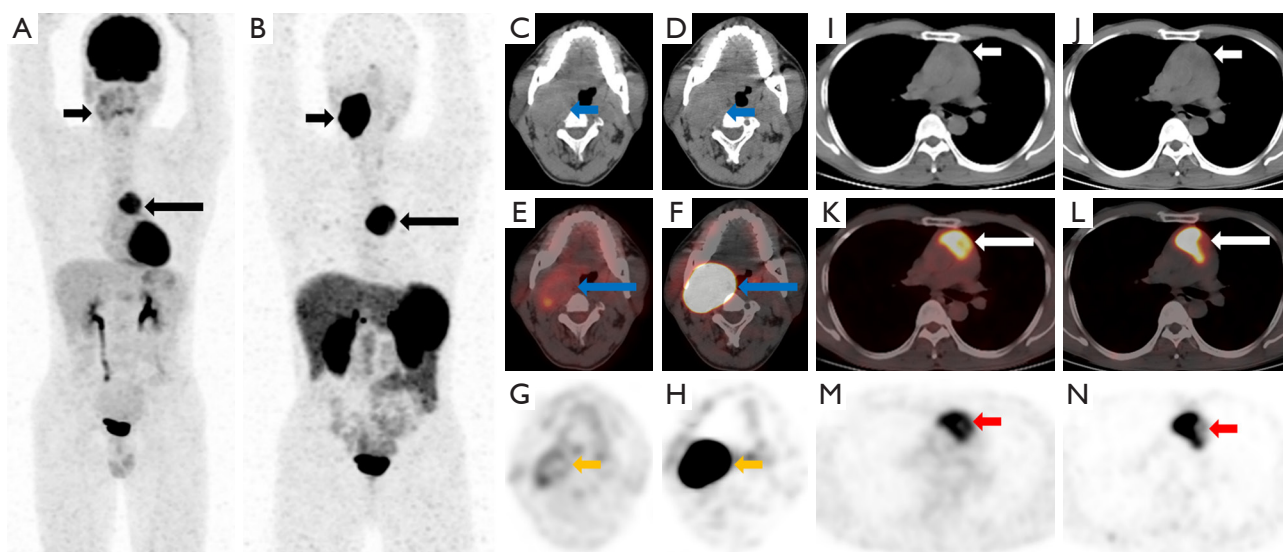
^{18}F -FDG and ^{68}Ga -DOTATATE PET-CT imaging of the right upper neck and the anterior mediastinum lesions. (A,B) MIP. The short black arrow indicates the neck region, and the long black arrow indicates the thoracic region). (C,D: short blue arrow) Axial CT of the neck and chest. (E,F: long blue arrow) FDG PET-CT fusion images. (G,H: orange arrow) PET imaging. (I,J: short white arrow) Axial CT of the chest. (K,L: long white arrow) DOTATATE PET-CT fusion imaging. (M,N: red arrow) PET imaging revealed a soft tissue mass in the right neck and anterior mediastinum with increased ^{18}F -FDG and ^{68}Ga -DOTATATE uptake. ^{18}F -FDG, ^{18}F -fluorodeoxyglucose; ^{68}Ga -DOTATATE, ^{68}Ga -DOTA(0)-Tyr(3)-octreotate; PET-CT, positron emission tomography-computed tomography; MIP, maximum intensity projection.
